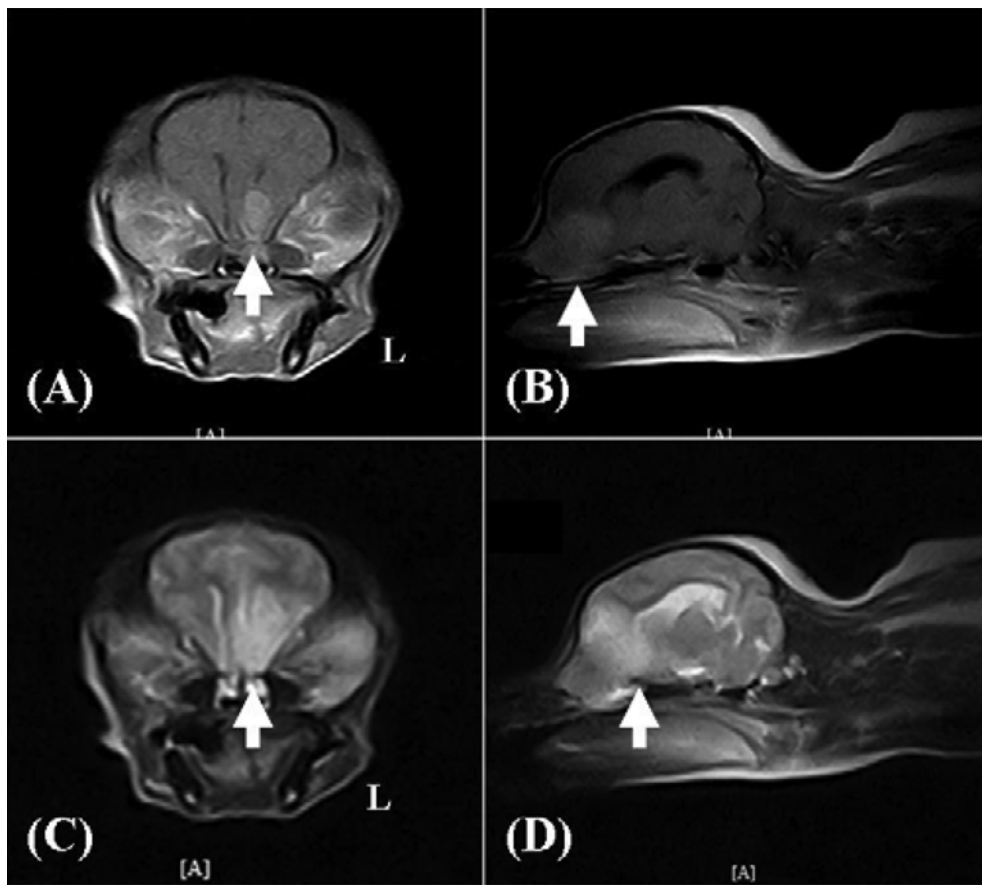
MR images of the present case. A: Post-contrast transverse T1-weighted image. Enhanced lesion is shown at the left cerebral parenchyma (arrow). B: Post-contrast sagittal T1-weighted image. Enhanced lesion is located cranial part of forebrain (arrow). C: Transverse T2-weighted image of same level with the panel A, a well defined hyperintense lesion is seen (arrow). D: Sagittal T2-weighted image of same level with the panel B.
